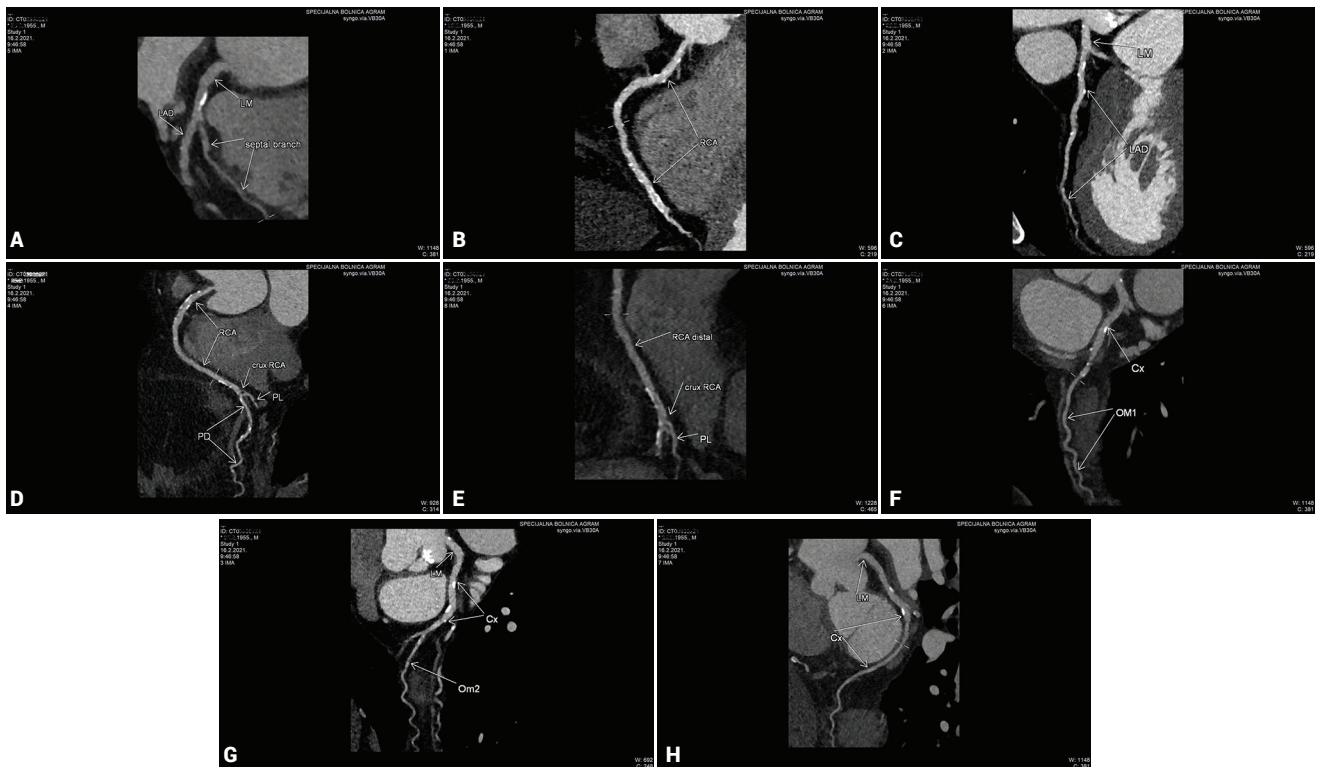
Male patient, 65 years old, with a heart rate of 60 bpm after intravenous application of metoprolol, with obesity (body mass index 34.2 kg/m²; chest/waist circumference 104/101 cm). Major epicardial vessels have segmentally longer calcifications but without major “blooming” artefacts (the left main artery and the right coronary artery) (A, B, C). Although images of side and even terminal branches of major epicardial vessels are slightly grainy, they still allow accurate analysis (D, E, F, G, H). Coronary computed tomography angiography revealed non-obstructive coronary artery disease.
